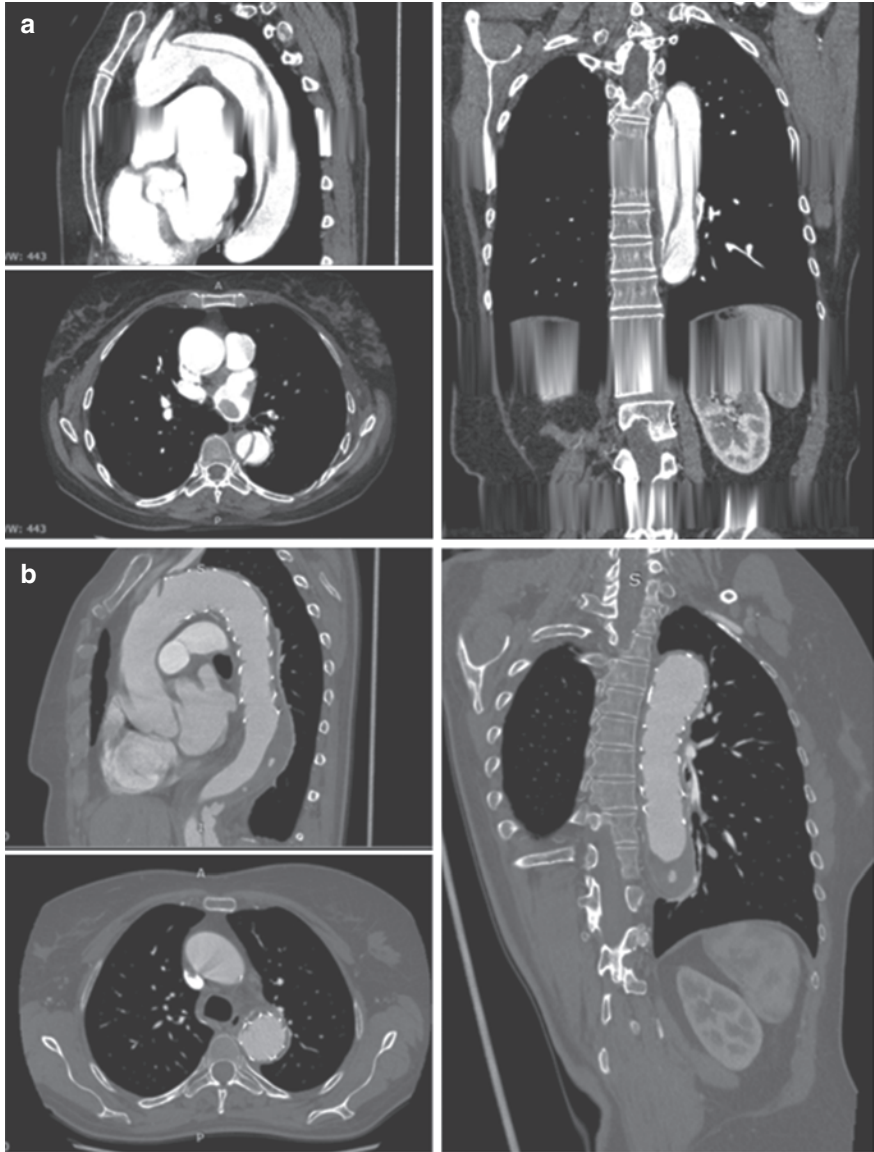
Contrast-enhanced computed tomography (CT) scan with multiplanar reconstruction of type B acute aortic dissection (AAD) complicated by malperfusion before (a) and after thoracic endovascular aortic repair (b). (Courtesy of the Cardiac Surgery Department, Federico II Medical School University, Naples, Italy). Reprinted, with permission, from Bossone E, et al. Acute Aortic Syndromes: Diagnostic and Therapeutic Pathways. Heart Fail Clin. 2020;16(3):305–315 [9]
